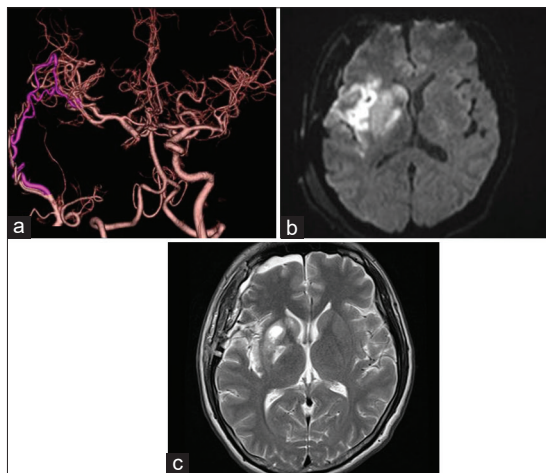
Postoperative imaging. (a) computed tomography angiography showed good patency of the superficial temporal artery-middle cerebral artery bypass and recanalization at the superior-most aspect of the internal carotid artery. (b) Diffusion-weighted image showed no additional infarction. (c) T2 imaging 2 weeks postonset showed hyperintensity on the posterior limb of the internal capsule and basal ganglia.
